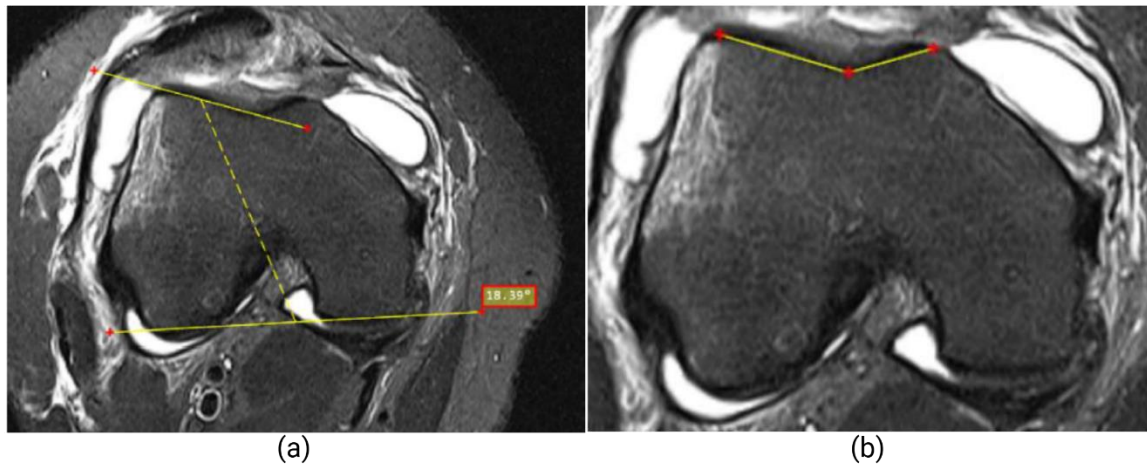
Axial MRI of a right knee.
